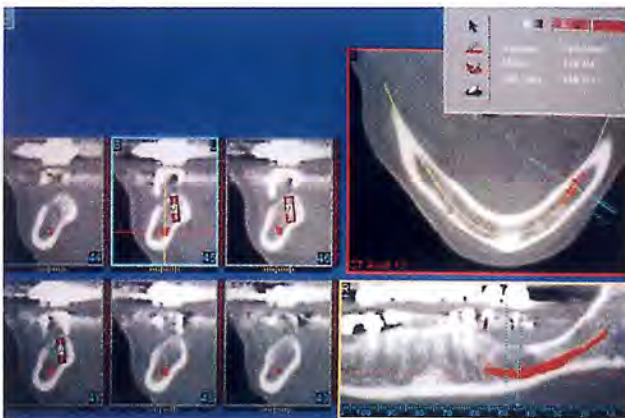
The inferior alveolar canal can be painted in the images where it can be identified in the reformatted CT scan images. The software will then transfer these markings to the other images.
